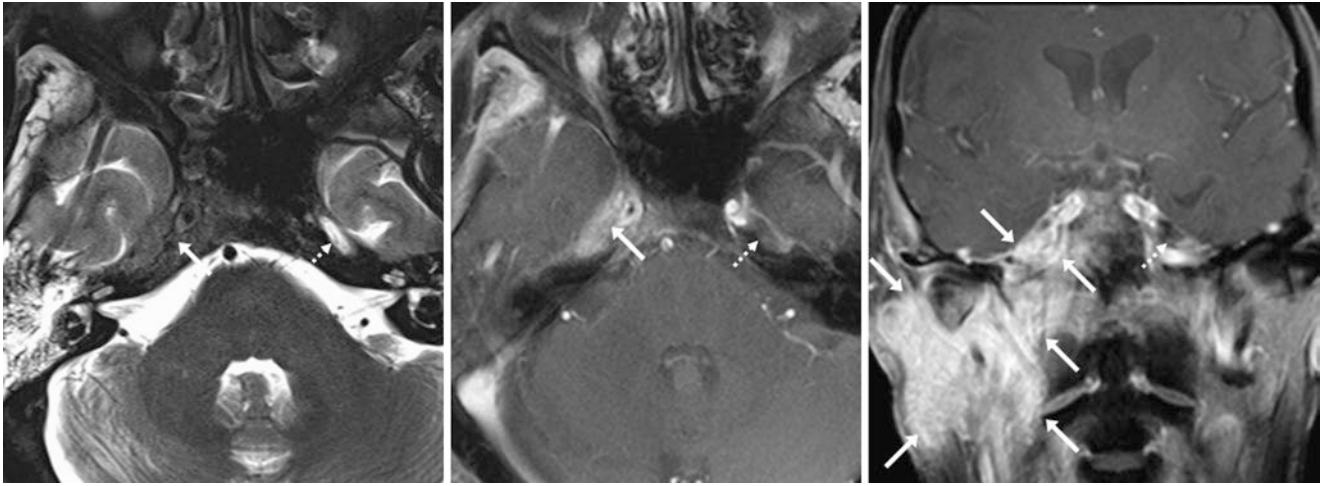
Comparison case of squamous cell sarcinoma (SCCa). A 54-year-old with SCCa underwent 1.5 T MRI axial T2WI (*left*), post-contrast fat-suppressed axial (*middle*), and coronal (*right*) T1WIs, which depicted a replaced, T2-dark right cavernous sinus and Meckel
